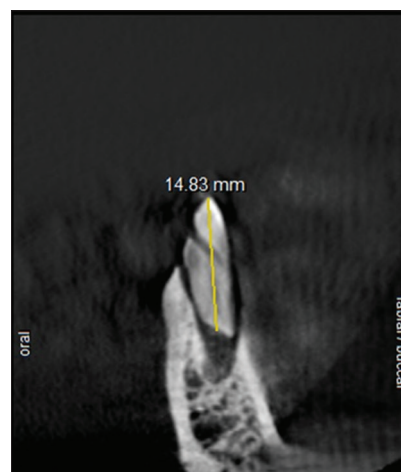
Cross-sectional view in cone-beam computed tomography of mounted teeth with working length measurement.
